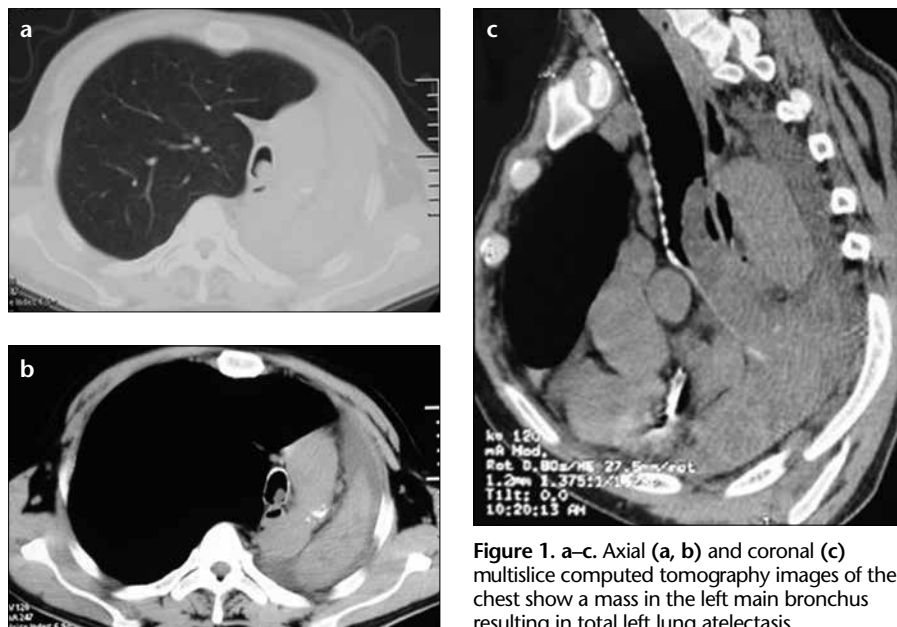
a–c. Axial (a, b) and coronal (c) multislice computed tomography images of the chest show a mass in the left main bronchus resulting in total left lung atelectasis.
